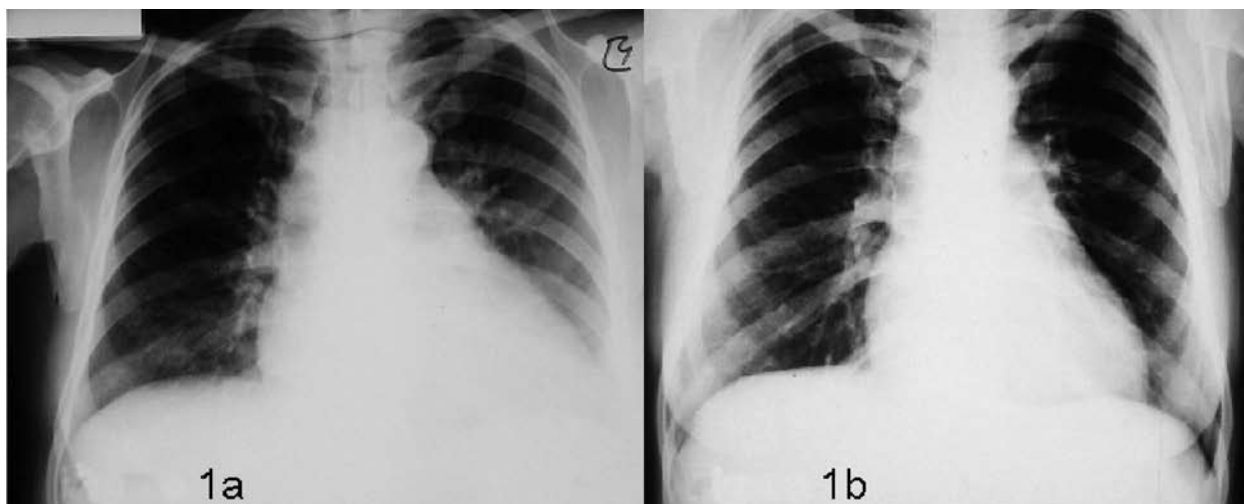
(a) Chest roentgenogram showing cardiomegaly with prominent pulmonary arteries and left pleural effusion; (b) chest roentgenogram taken three months later showing normal heart without left pleural effusion.
